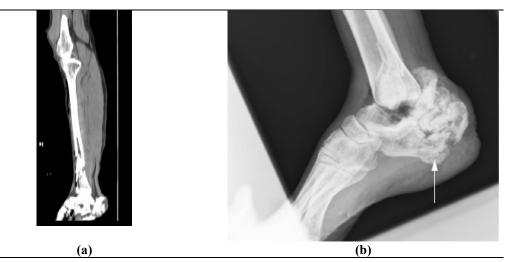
(a) Example of a mounted casualty with tibial, fibular and calcaneal fracture. (b) Close-up radiographic image of an exemplar calcaneal injury associated with mounted blast casualties, with the arrow denoting the calcaneal fracture.
